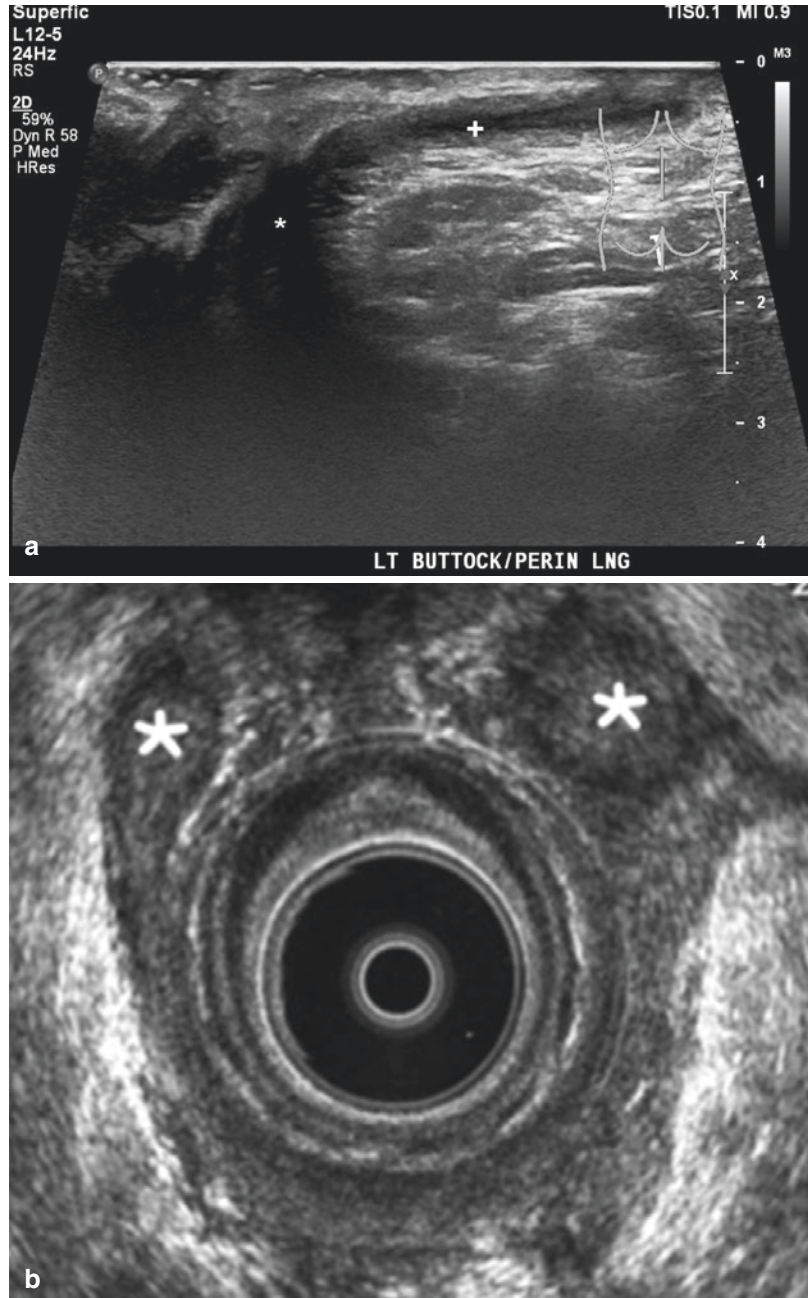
Anal endosonogram. (a) Longitudinal ultrasound image of the medial left buttock; * denotes air in the anus; + denotes a hypoechoic perianal fistula extending to the skin surface caudad to anus. (b) Horseshoe abscess. * Presence of horseshoe abscess around the anal canal
